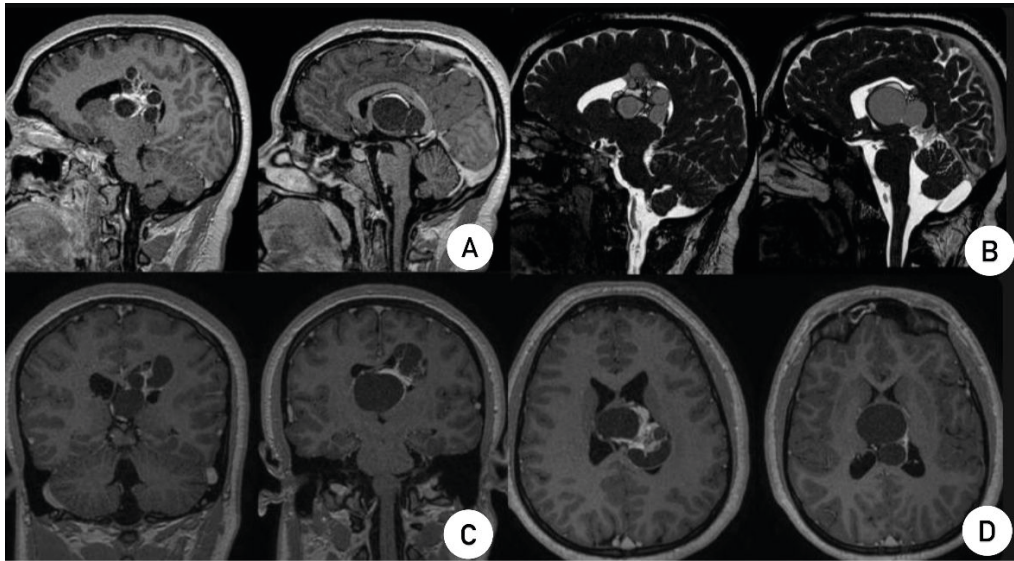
A- Axial T2 FLAIR MRI section; B- Sagittal section of MRI with Fiesta weighting; C- Coronal T1-weighted MRI section; D- Axial T1-weighted MRI section. Cranial MRI with the appropriate cuts and sequences showing solid/cystic content measuring approximately 5.2 x 3.9 x 5.0 cm in the left lateral ventricle, obliterating the left foramen of Luschka and causing dilation of the lateral ventricle.
